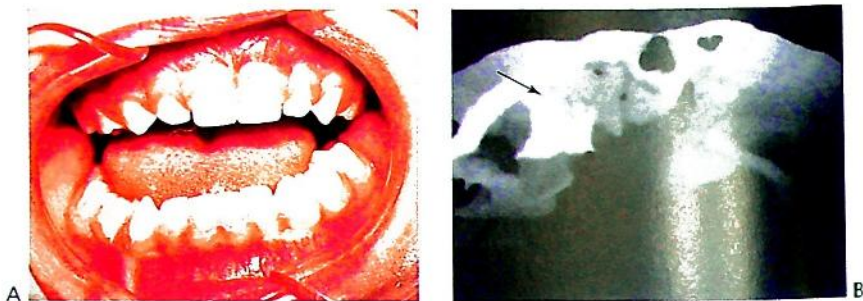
(A,B) Mandibular asymmetry caused by a dislocation of the left condyle after play equipment fell on this young girl. Imaging of these injuries can be difficult and in this case a CT scan was performed with 3-dimensional reconstruction to detail the injury. The CT demonstrates the dislocation, with the condylar head (arrow) anterior to the articular eminence and lying under the zygomatic arch. As is common with these injuries in children, an intracapsular fracture-dislocation is present, which remodelled itself without treatment. Normal function was achieved within 6 months.
